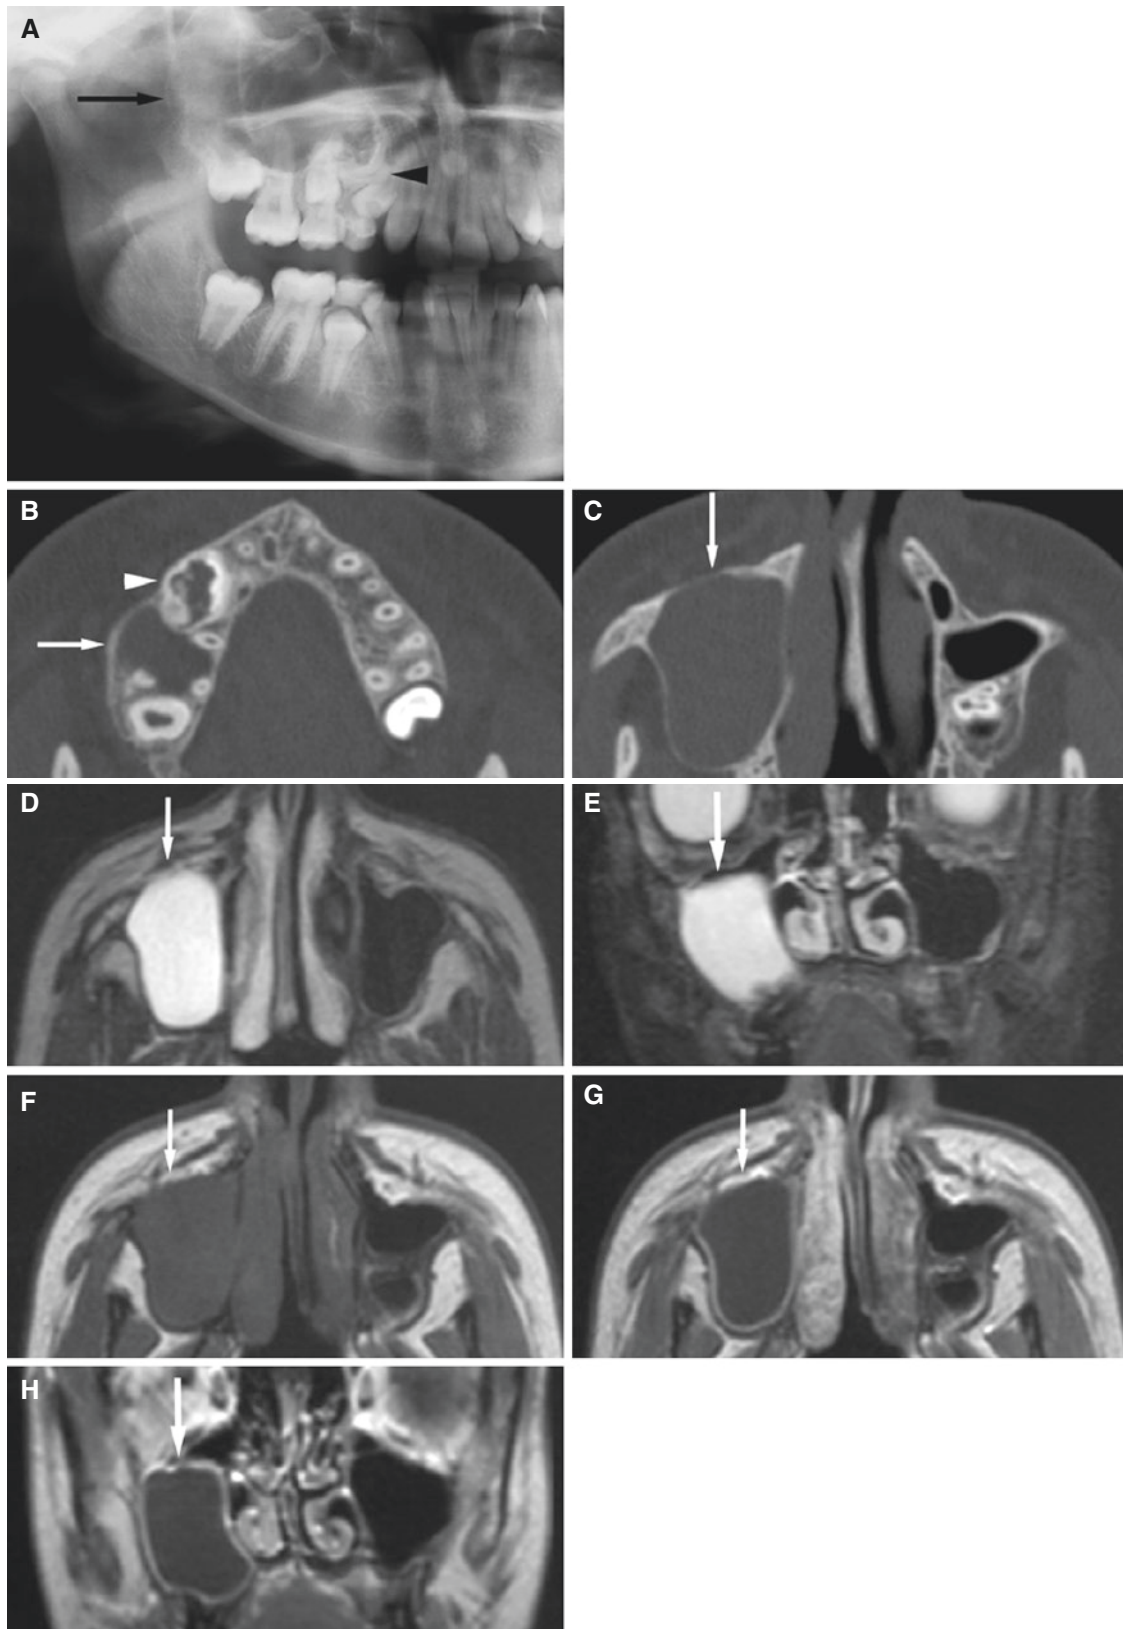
Follicular cyst, maxilla; 13-year-old female examined for unerupted maxillary right first premolar. (A) Panoramic view shows expansive process, partially with sclerotic outline (*arrow*) in the right maxillary sinus, and an odontoma (*arrowhead*). (B) Axial CT image shows expansive radiolucency and root resorption (*arrow*) and complex odontoma (*arrowhead*) in alveolar process. (C) Axial CT image shows process occupying the entire maxillary sinus with expanded walls
